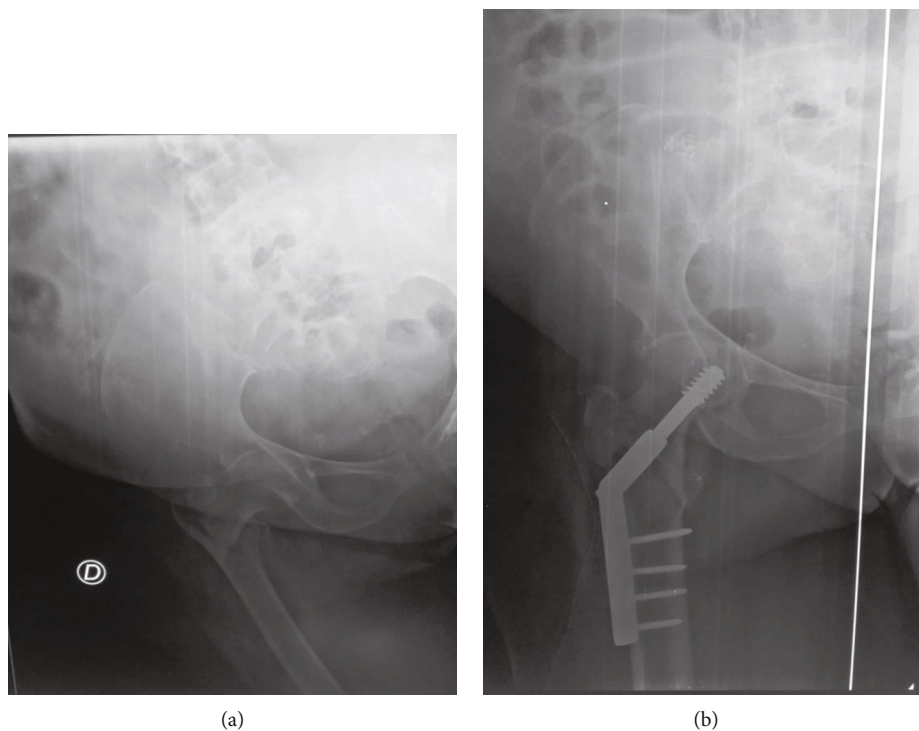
X-rays of patient 4. (a) Pertrochanteric fracture type 31A1.3 AO/OTA. (b) Osteosynthesis by DHS.
